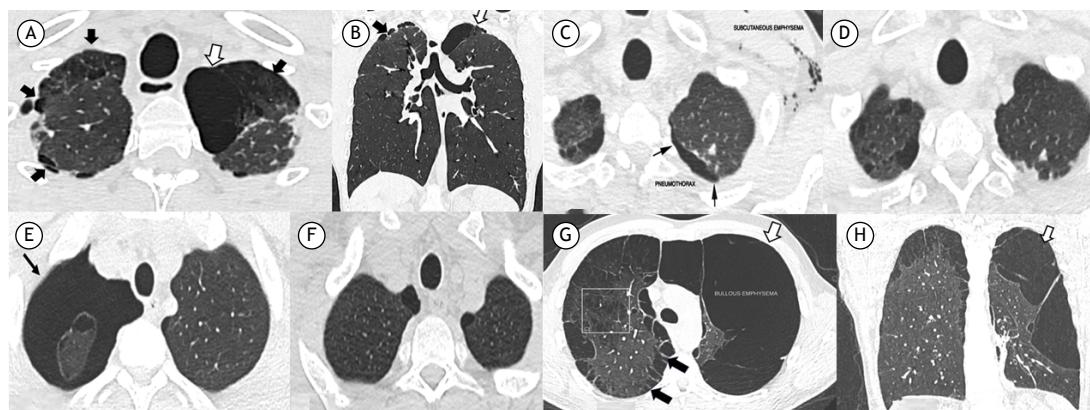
Axial and coronal unenhanced thin-slice chest HRCT scans (A and B, respectively) in a 25-year-old male cannabis smoker, showing a large (5 cm) bulla (white arrows), sharply demarcated by a thin wall in the left lung apex, together with multiple small blebs adjacent to the pleura and small areas of paraseptal and centrilobular emphysema in both lung apices (black arrows). Axial unenhanced thin-slice chest HRCT scans (C and D, respectively) in a 45-year-old male cannabis smoker, showing left pneumothorax (arrows in C) with marked bilateral apical subcutaneous emphysema and sparse areas of paraseptal emphysema along with small blebs and rare bullae that resolved after drainage. Axial unenhanced thin-slice chest HRCT scans (E and F, respectively) in a 23-year-old male cannabis smoker, showing extensive pneumothorax on the right side (black arrow in E) with some blebs adjacent to the visceral anterior pleura and small areas of paraseptal emphysema on the same side, with complete resorption of pneumothorax after chest drainage. Axial unenhanced thin-slice chest HRCT scan (G) in a 32-year-old male cannabis smoker, showing extensive alterations due to destruction of lung tissue on both sides with a coarse bullous formation on the left (white arrow). Coronal multiplanar reconstruction (H) of the same patient showing the bullous formation occupying the upper and middle thirds of the left hemithorax, with subtle septation. In the right lung (visible in G), there were marked changes from paraseptal and centrilobular emphysematous damage (black arrows and square outline, respectively).
